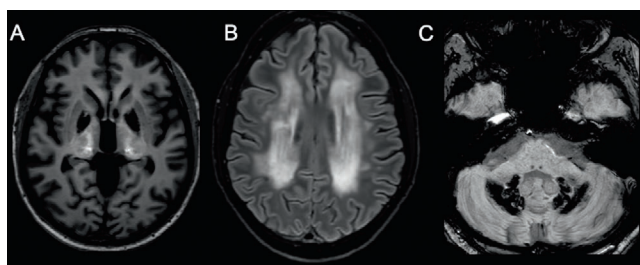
Brain MRI in PFBC. A: T1 sequence: basal ganglia calcifications in PFBC. B: FLAIR sequence: extensive leukoencephalopathy in a PDGFB mutation carrier. C: SWI sequence: dentate nuclei and brainstem calcifications in a MYORG mutation carrier.
